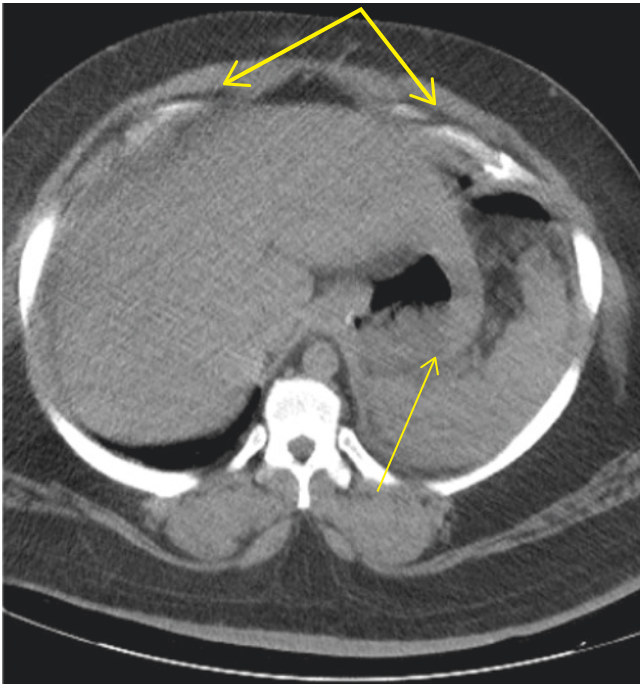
Non-contrast CT of the abdomen and pelvis of patient with abdominal pain 10 days after sleeve gastrectomy. Large arrows, intra-peritoneal free air; small arrow, suspected gastric content outside of the stomach, concern for staple line leak
